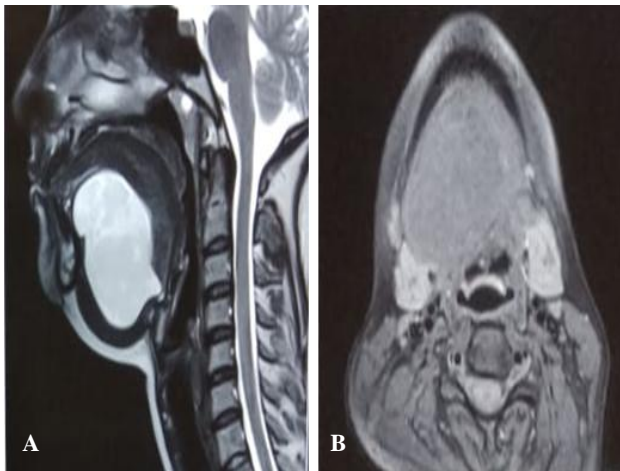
(A) Sagittal and (B) axial MRI neck scans, 5 cm well circumscribed sublingual cystic mass suggestive of sublingual dermoid cyst.
